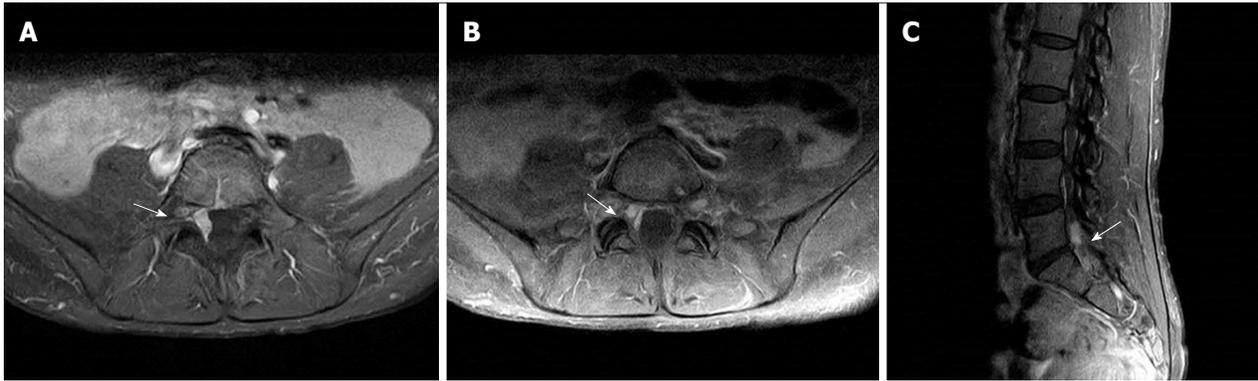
Magnetic resonance imaging of the lumbosacral spine. Axial (A, B) and sagittal (C) contrast-enhanced T1-weighted imaging of the spine MRI shows a focal dural mass with invasion to the right L5 and S1 nerve roots at the L5-S1 level. MRI: Magnetic resonance imaging.
